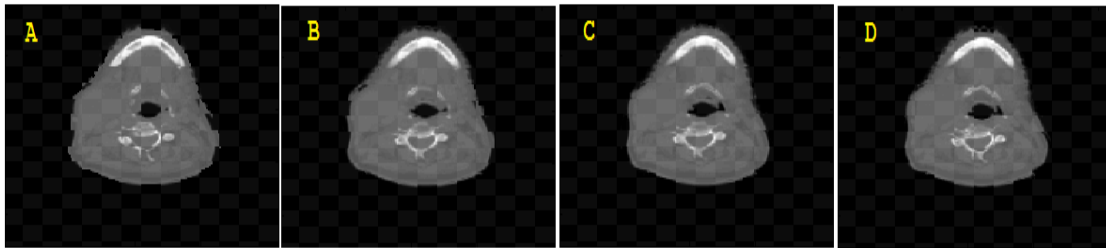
Checkerboard image of mid axial slice of the CBCT and LDIR with different ϵ values, 0 (A), 10 (B), 50 (C), 1000 (D).
